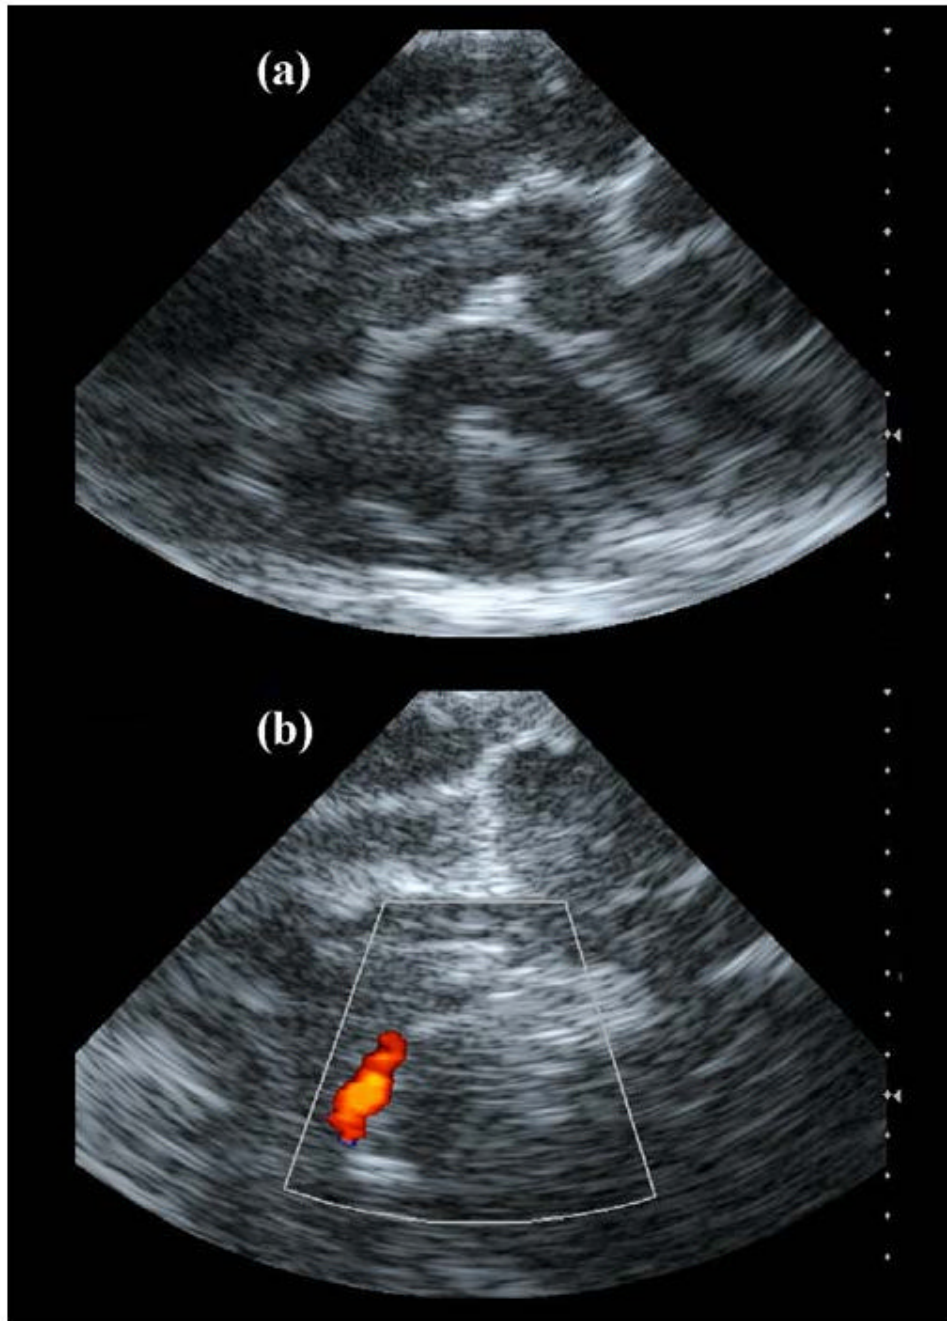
Intracranial AcuNav images. (a) Echo image showing various gyri and sulci of the cerebrum. (b) Color Doppler image showing the internal carotid artery.
